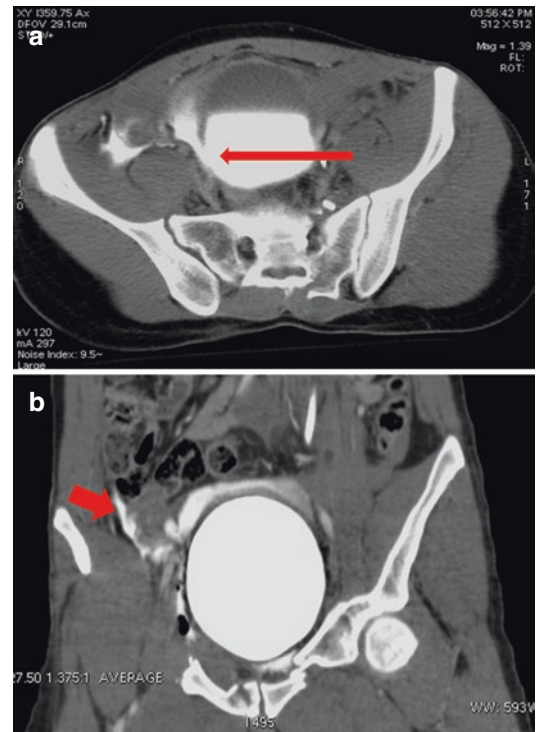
Urinary bladder intraperitoneal rupture; axial (a) and coronal (b) reformatting image of a CT cystography. Laceration of the left bladder wall seen as a defect in wall contour (*long arrow*) and contrast extravasation outlining peritoneal space (*short arrow*)
